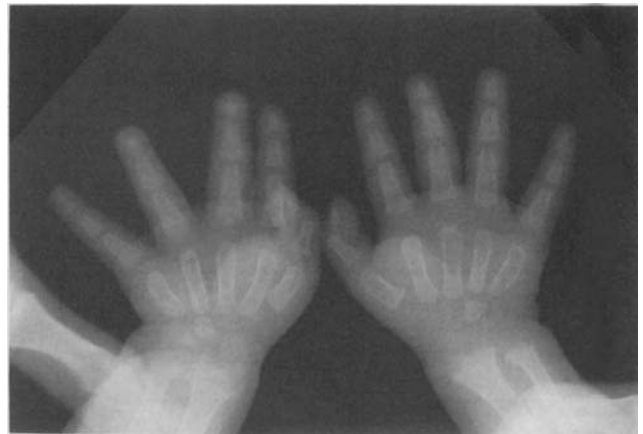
Roentgenogram of the hands.
